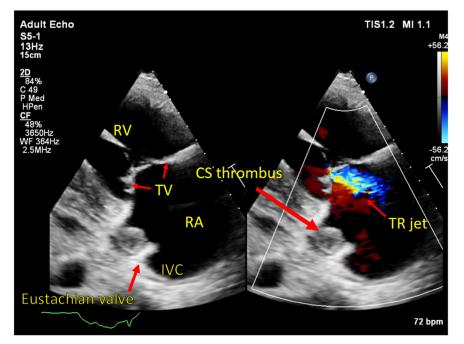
Two-dimensional TTE, parasternal long-axis right ventricular inflow view, systolic phase without (*left*) and with (*right*) colorflow Doppler, demonstrates a large thrombus (*long arrow*) in the CS. The TV leaflets (*small arrows*), the Eustachian valve (*short arrow*), and TR (*arrow*) are also seen on the image. *TR*, tricuspid regurgitation; *TV*, tricuspid valve.
